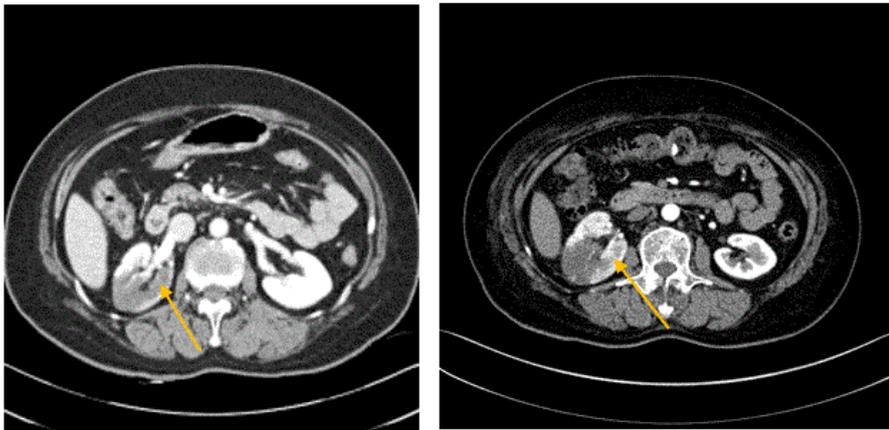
Axial section of CT scan of the patients. Hypo-attenuated lesion was showed in right kidney on admission day CT. the extent of hypo-attenuated lesion was decreased on 8th admission day CT (yellow arrow).
